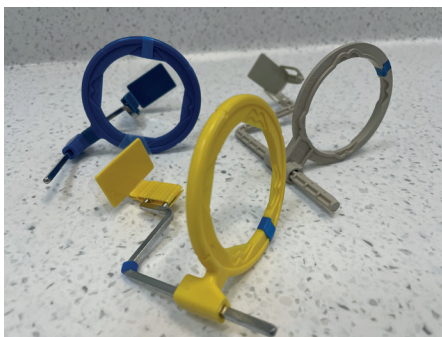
(a,b) Long-cone film holders, together with an EndoRay II Film Holder (Rinn, Dentsply Sirona, Charlotte, NC, USA) and being used clinically. The latter film holder was developed so that it can be used peri-operatively to determine working length with files in the canals (diagnostic file radiograph) or gutta percha cones placed to length to verify the extent of canal preparation prior to obturation in the case of a cone fit radiograph.
